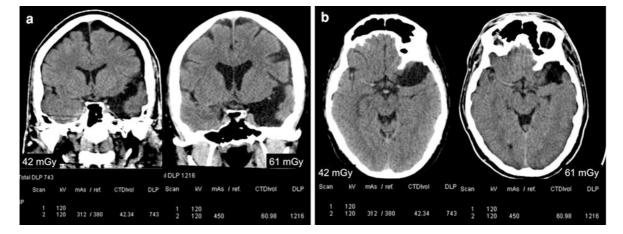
Two consecutive brain CT examinations with 3 months' interval (the first one is displayed on the right) in a 42-year-old man who had a motor vehicle accident. Acquisitions were obtained at 120 kV and with a collimation of 16×0.6 mm. The right one was obtained with fixed tube current at 450 effective mAs and resulted in a CTDIvol of 61 mGy. The *left one* (a control scan 3 months after the injury) was obtained with tube current modulation, reference quality image setting at 380 mAs, and mean effective tube current time
